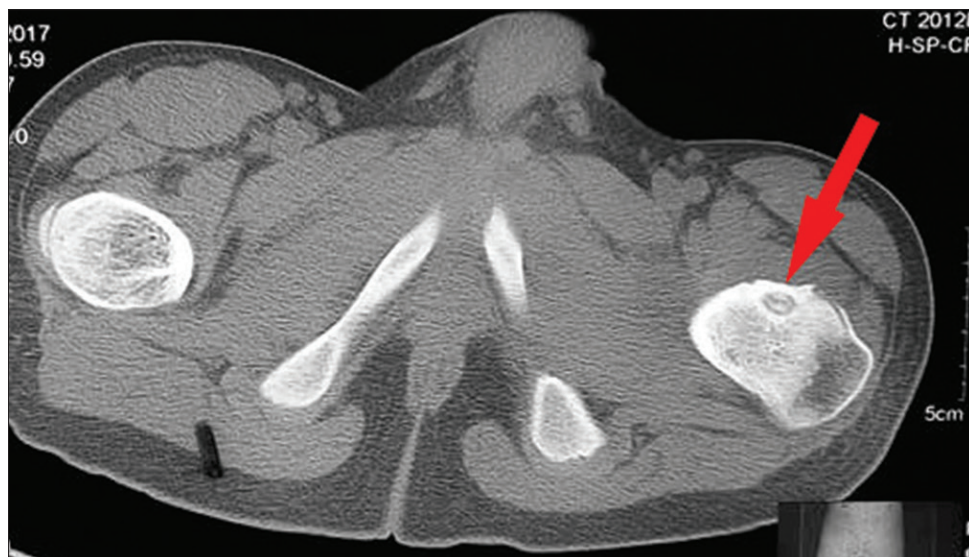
Axial section of computed tomography scan showing nidus in its subcortical location and anterior neck (Red arrow)
